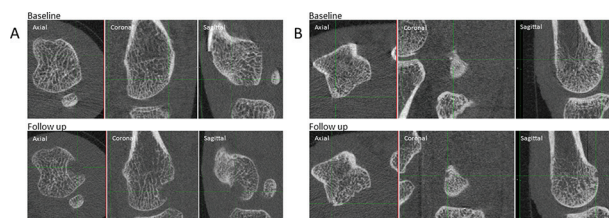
High resolution peripheral quantitative computed tomography images of bone changes. (A) New active erosion at follow up in a patient characterized by diffuse/wolly lining. (B) New active erosion at follow up in a control.
